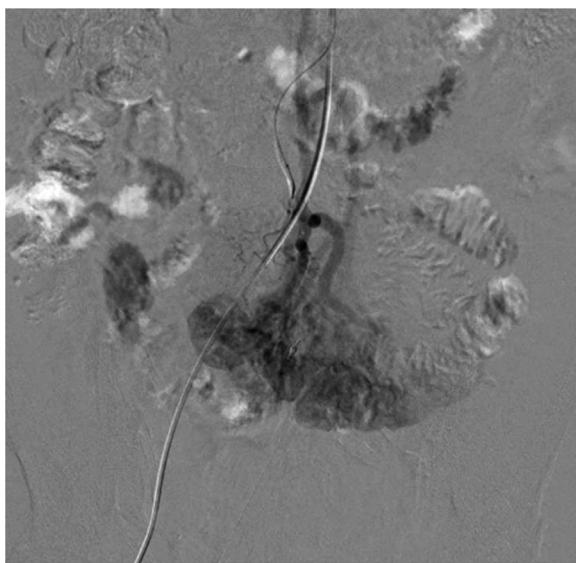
AVM in branch of ICA according to CT angiography.
